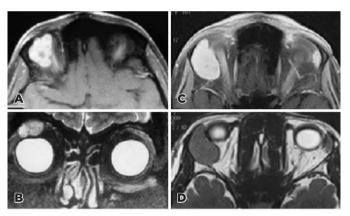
Primary lacrimal gland pleomorphic adenoma (PA; A, B) and adenoidcystic carcinoma (ACC; C, D) A: Post-contrast T1-weighted MRI shows lobulated heterogeneous contrast enhancement(PA) B: T2-weighted coronal MRI shows a hyperintense (bright) tumor(PA) C: Post-contrast T1-weighted MRI shows unlobulated homogeneous contrast enhancement (ACC) D: T2-weighted axial MRI shows a hypointense (dark) tumor (ACC) with respect toextraocular muscle.
